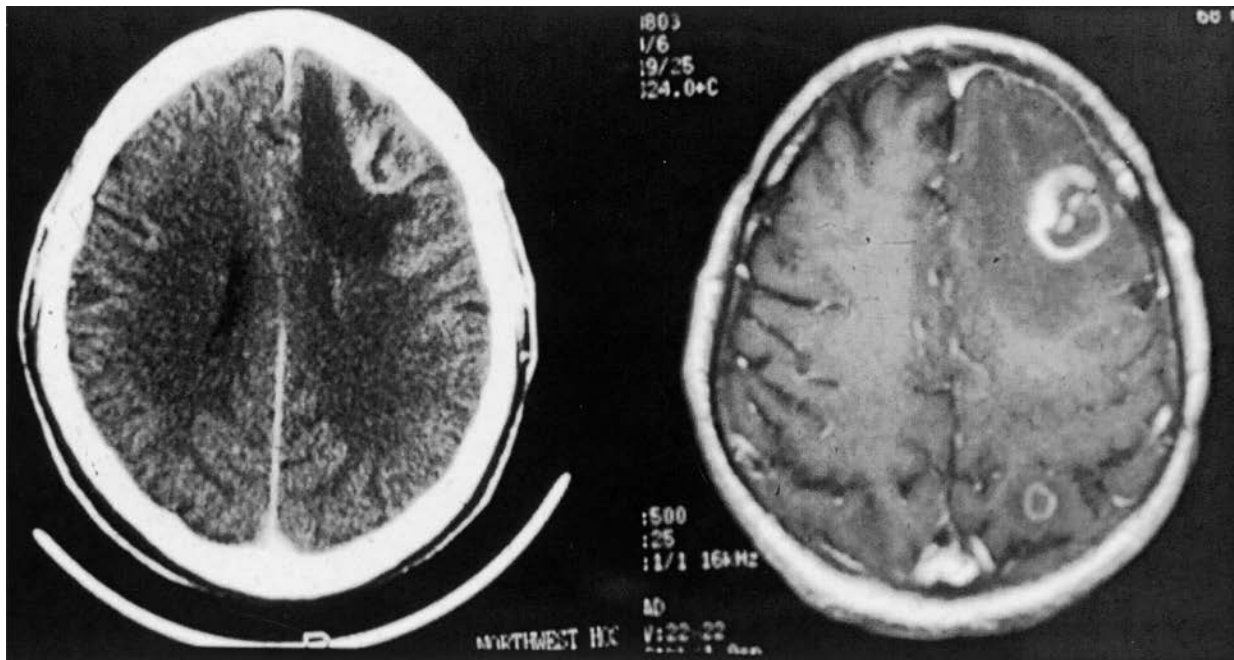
CT scan (left panel) showing a single contrast-enhancing lesion in toxoplasmosis. Right panel: MRI from same patient showing multiple contrast-enhancing 'ring' abscesses, with surrounding edema.
